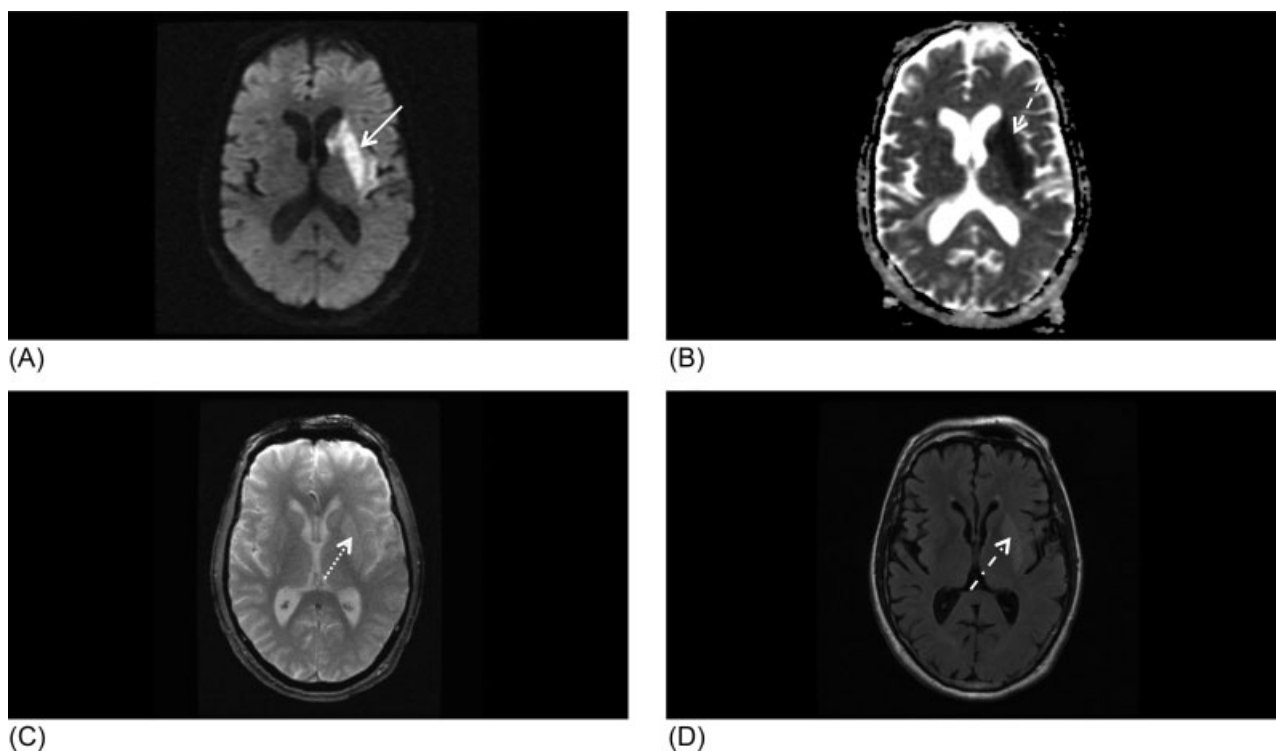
MRI image of brain without contrast. (A) Diffusion-weighted image in left MCA distribution (solid arrow). (B) ADC map corresponding to areas of restricted diffusion positivity (dashed arrow). (C) Gradient recalled-echo (GRE) image showing no evidence of hemorrhagic conversion, which would appear black on the film (dotted arrow). (D) Fluid attenuation inversion recovery (FLAIR) image indicating that the stroke is >24 hours old (dashed dotted arrow).
